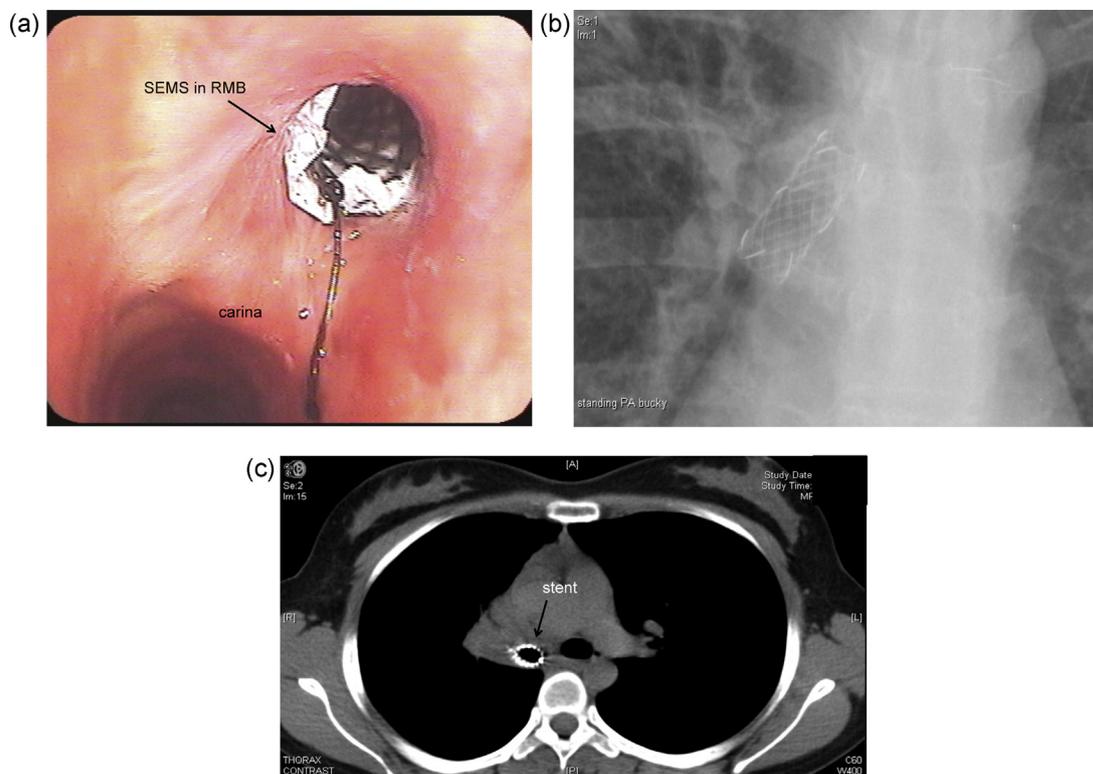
(a) Bronchoscopic image at carina with SEMS (self-expanding metallic stent) in the RMB. (b) X-ray image post-stenting, showing the fully expanded SEMS keeping the RMB patent. (c) Computed tomography confirming the SEMS in the correct position.
